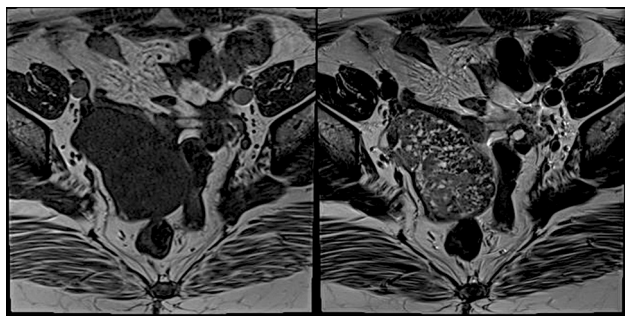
MRI demonstrates a 4.8×7.8 cm sized enhancing mass with diffusion restriction around right adnexa (heterogenous SI on T2WI and high SI on T1WI).
